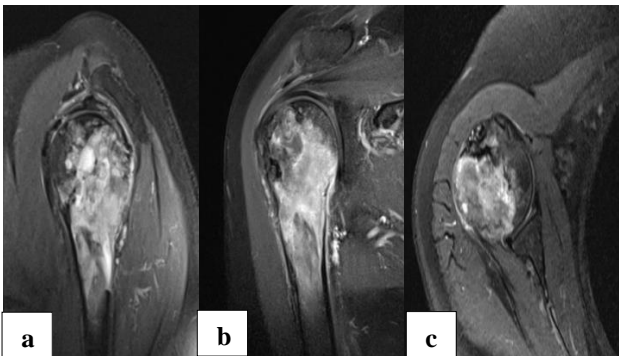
(a-c): MRI of the right shoulder of patient A showing aggressive, expansile lesion involving the proximal humerus causing cortical destruction and erosion with areas of both narrow and wide zone of transition and irregular calcified matrix. The lesion has variable signal with no lobulated bright signal areas.
